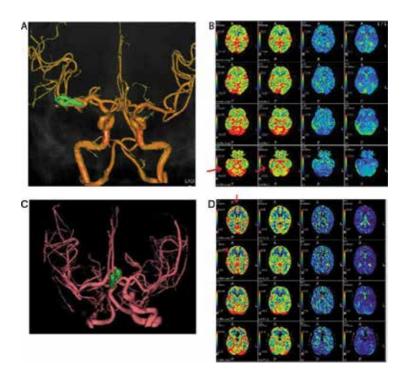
(A) A 72-year-old female underwent neurosurgical clipping of the right mid-cerebral artery due to the ruptured aneurysm at the age of 58 at the other hospital. Her CT angiography is shown in the figure. (B) CT perfusion findings revealed an apparent decrease of cerebral blood flow perfused by the right mid-cerebral artery (indicated by the arrows). (C) A 63-year-old woman underwent emergent neuroclipping surgery for the ruptured anterior-communicating artery aneurysm. Her CT angiography is shown in the figure. The surgery is successfully carried out. (D) Six months postoperatively, a physiotherapist noticed her slight memory defect, and CT perfusion was evaluated, which revealed an apparent hypoperfusion of both frontal lobes (indicated by the arrows).
